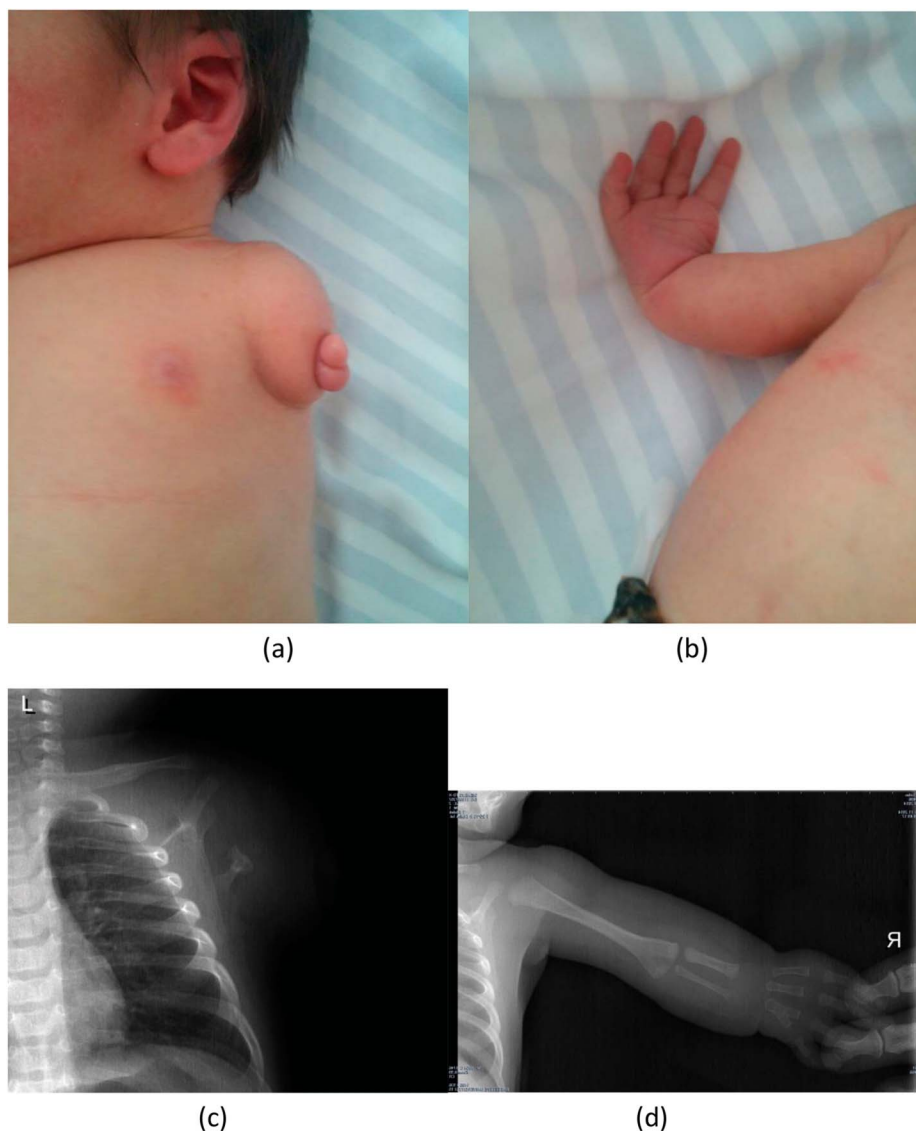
Transverser absence of left arm (Agenesis) (a); disgenesis of the right thumb (Level V according to the Blauth Classification) (b); X-ray of the left side (c); and X-ray of the right arm before splinting (d).
